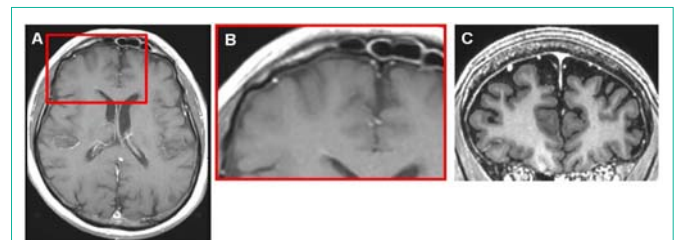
(A) Axial, (B) Axial Regional Enlargement, and (C) Coronal T1-weighted post-gadolinium images demonstrating resolution of the prior abnormalities 4 weeks later.
